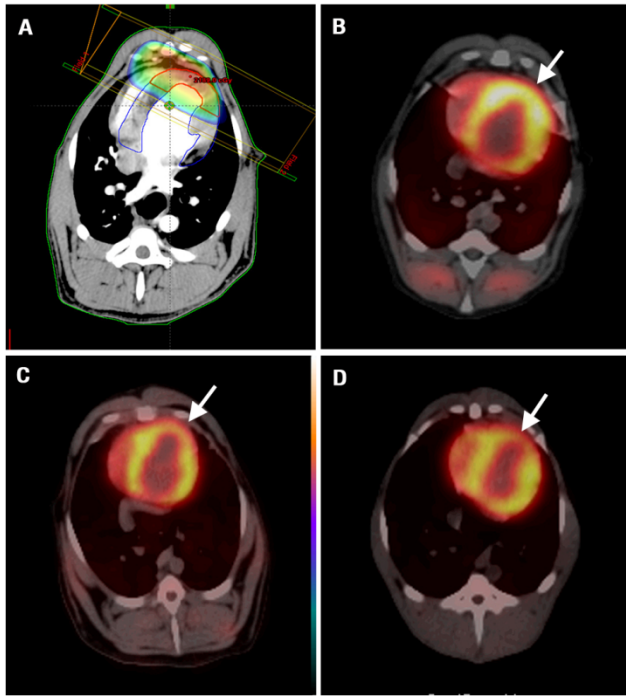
Radiation field and radiation dose distribution (A); PET/CT fusion images show that the scope of perfusion abnormality is consistent with the radiation field at three, six, and twelve month after irradiation (arrows, B-D).
